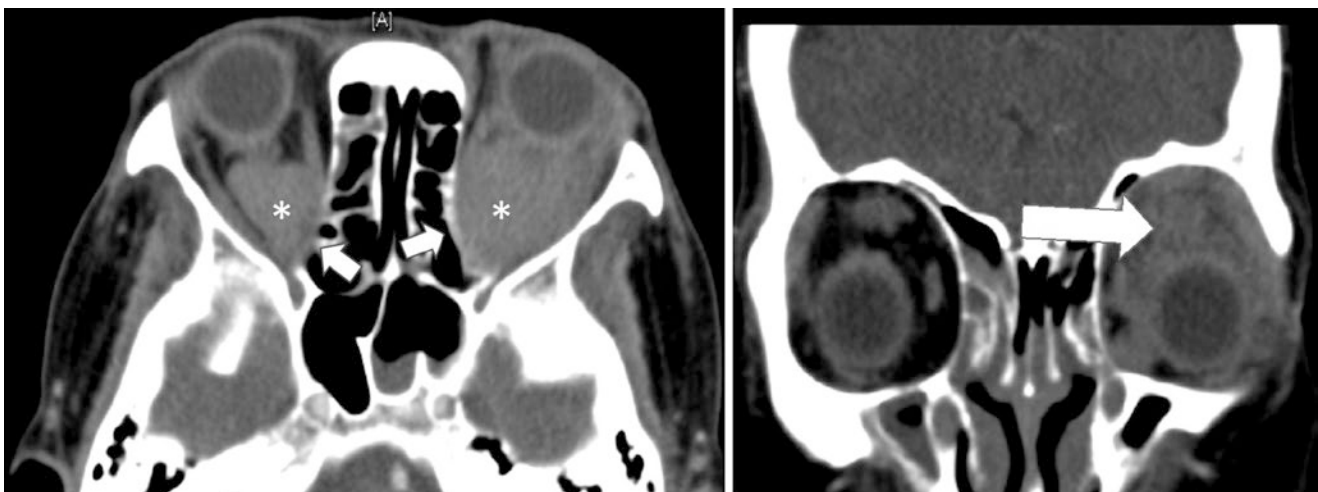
Left: Axial contrast-enhanced CT showing bilateral intraconal mass (*) with bowing of the posterior medial wall (white arrows). Right: Coronal contrast-enhanced CT showing infiltrative tumour involving the superior muscle complex (arrow)
